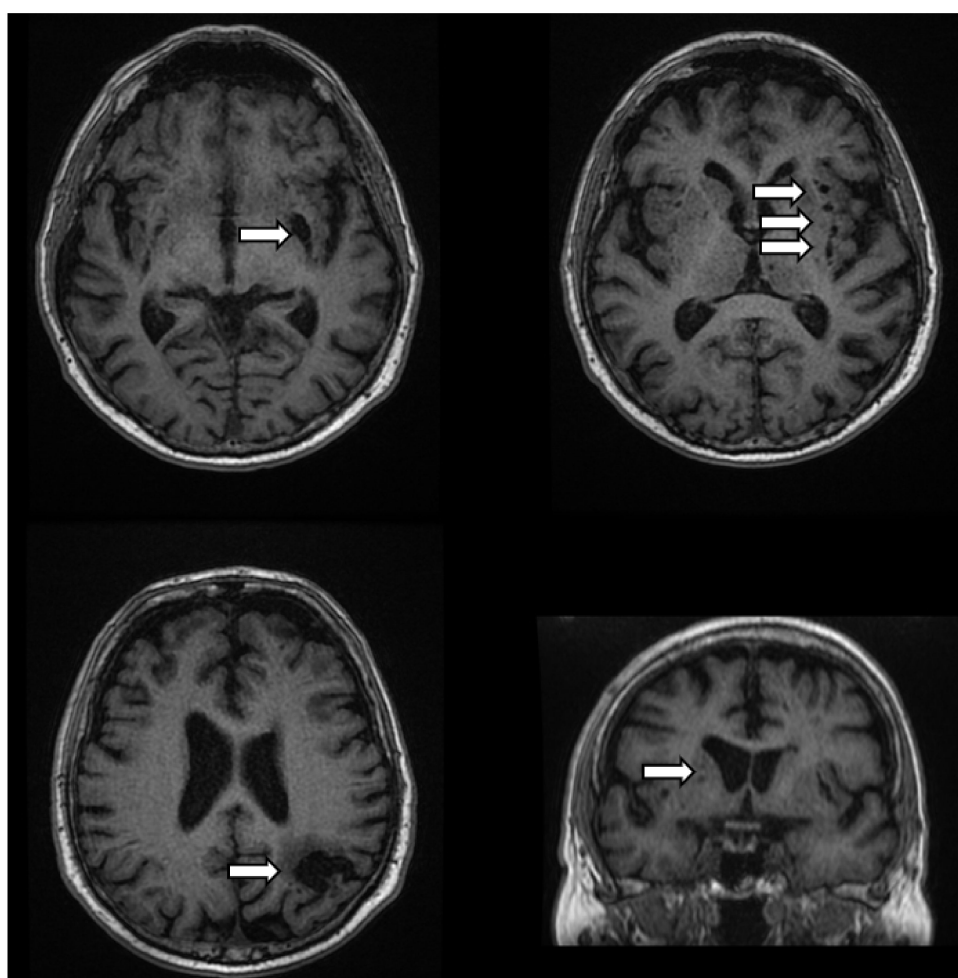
MRI scans of the 67-year-old patient with no neurological abnormalities but evident asymmetric lacunes (arrows), which were found coincidentally.
